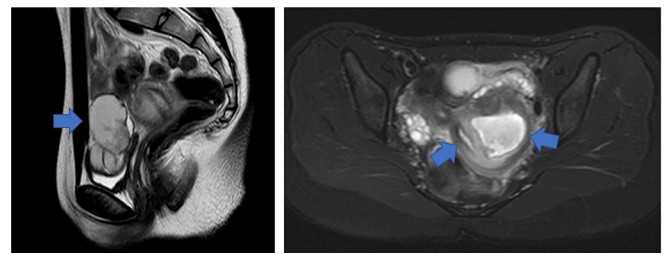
A) T2 MRI sagittal view: Oviductal hematoma is found on the ventral side of the uterus shows the left oviductal hematoma (indicated with arrows). B) T2 MRI in axial view: The two-uterine cavities and mass filled with fluid suggestive of blood retention on the left side resulting in the formation of the left oviductal hematoma.
